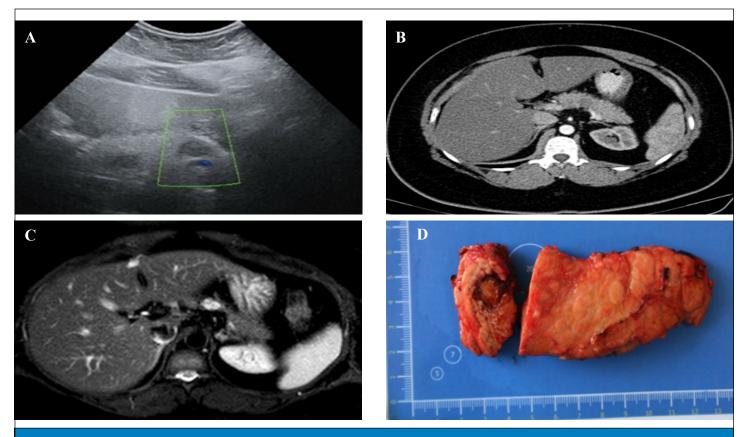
SPPT type 1: a — US image, duplex scanning; b — MSCT image; c — MR image; d - macroscopic appearance of the pancreas with SPPT
